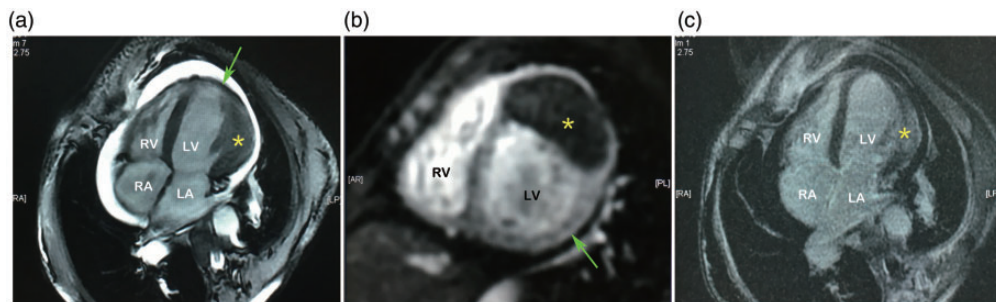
Cardiac magnetic resonance imaging (CMRI) with plain balanced steady-state free precession sequence (four cavities). (a) The surrounding white area indicates pericardial effusion. The tumor signal (yellow asterisk) is lower than normal in the left ventricular wall myocardium (green arrow). (b) CMRI enhanced initial hyperperfusion short-axis scan. Pericardial effusion shows low signal intensity with no enhancement. The myocardial enhancement signal is slightly higher than the tumor enhancement signal. (c) CMRI enhanced delayed scanning (four cavities, basically consistent with (a)). The delayed tumor (yellow asterisk) has a stronger signal than the normal left ventricular wall myocardium (green arrow).
